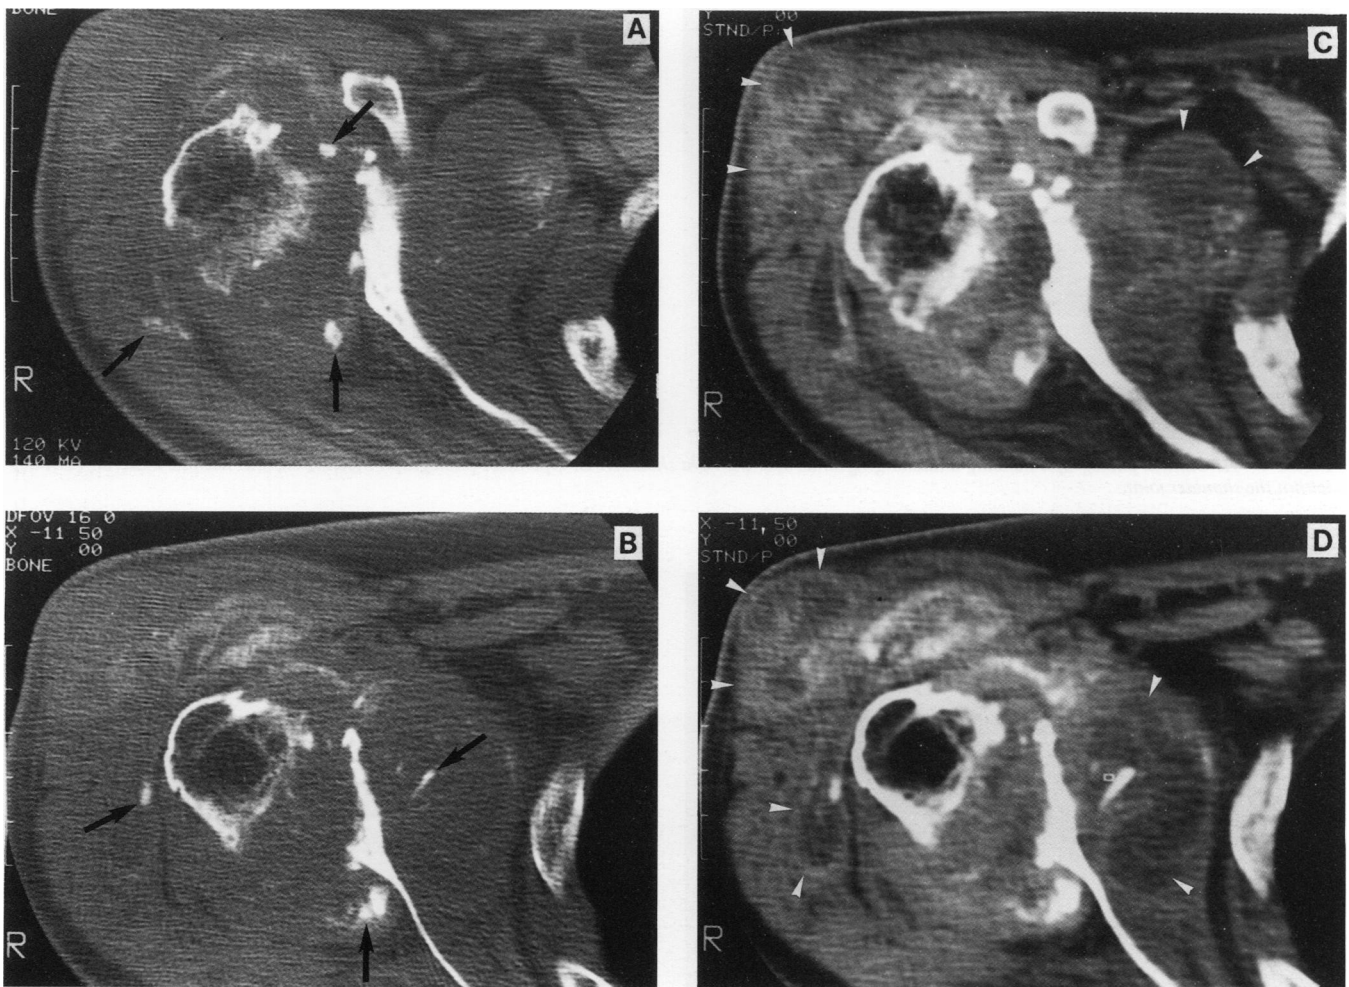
Axial CT images (bone window), at the levels of (A) the base of the coracoid process and (B) the mid-glenoid fossa, show marked destruction of the glenohumeral joint with multiple small bony fragments (arrows). Enhanced CT images (soft tissue window) at corresponding levels (C and D), show multiple ring shaped enhancing lesions within the swollen deltoid and subscapularis muscles (arrowheads). An inflammatory mass is seen in the glenohumeral joint.
